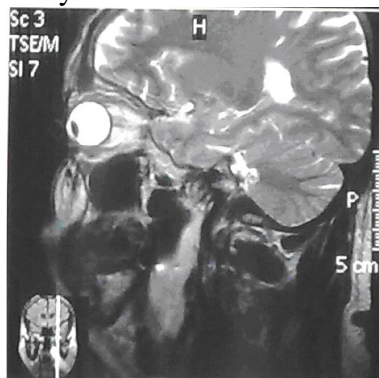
MRI showed a mass in left parapharyngeal space proved as lipoma.
